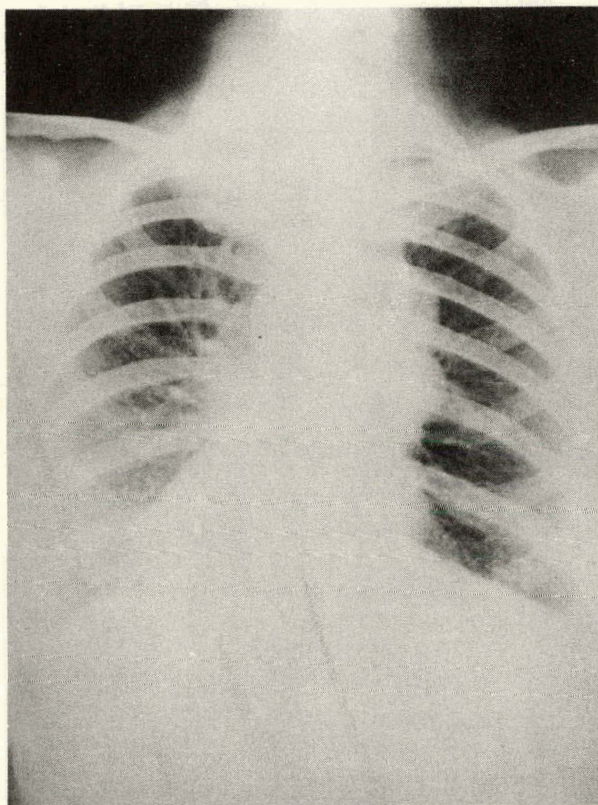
Roentgenograph of chest. Note large mediastinal masses. A large mass is also present in left superior mediastinum deviating the trachea to the right.
